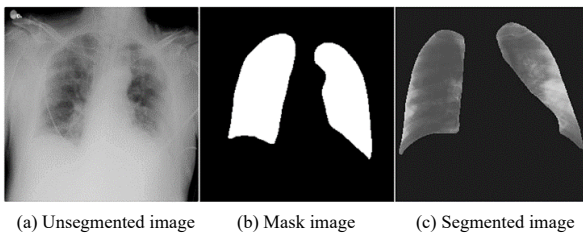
Figure (a-c) demonstrating unsegmented image, respective mask image and segmented chest x-ray image
